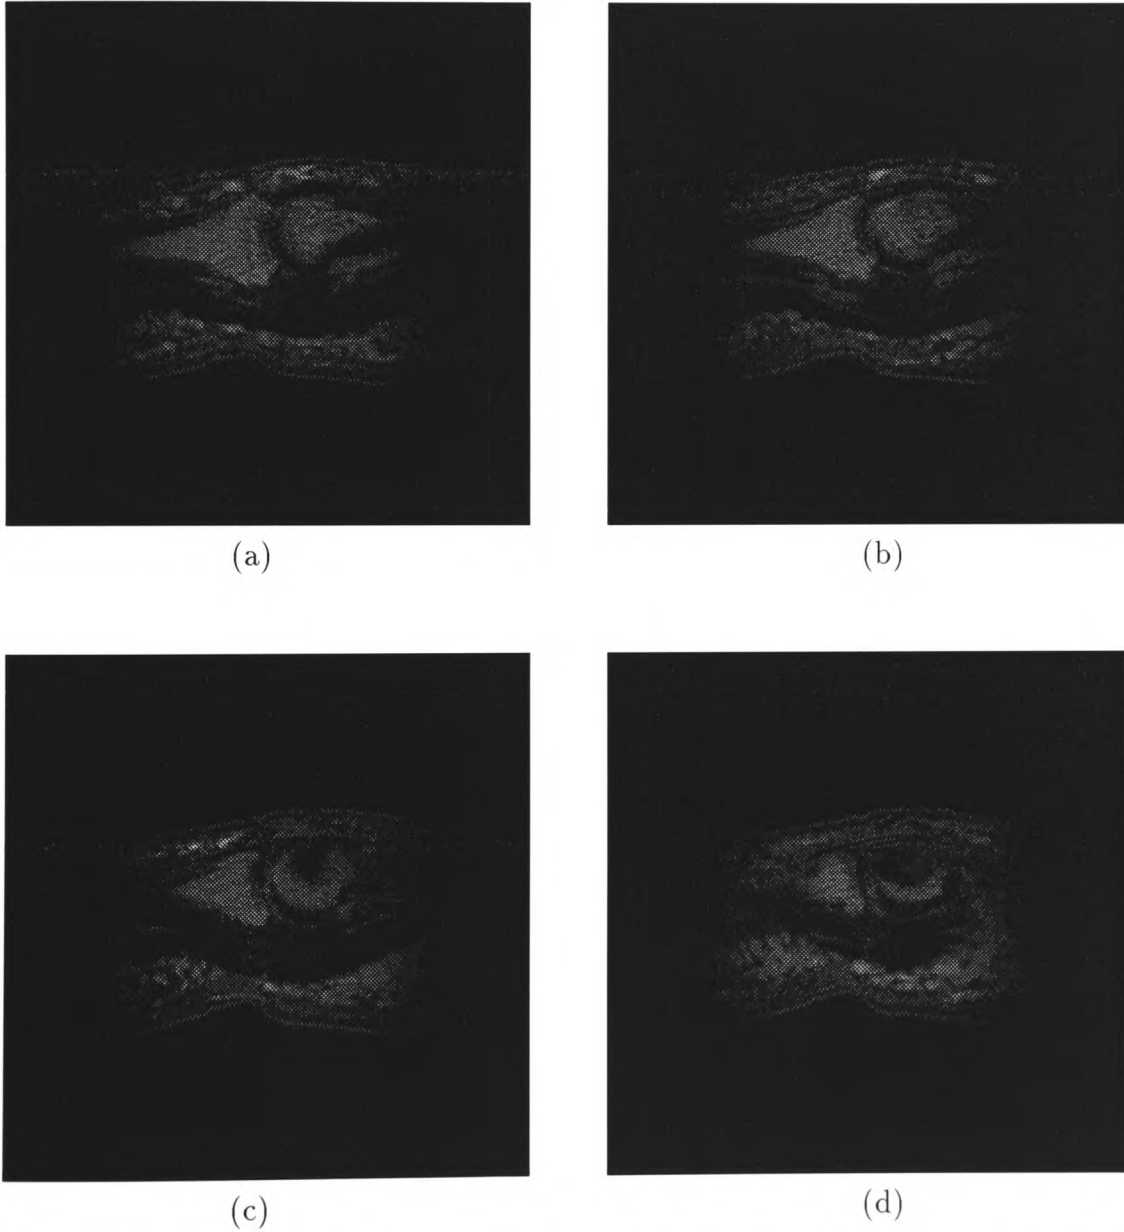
(a) to (d) Subject 1 second occasion T2-weighted image slices 1 to 4 respectively.
